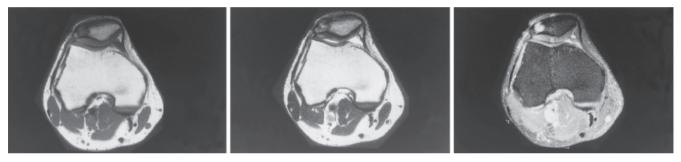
a Magnetic resonance imaging (MRI) reveals an intraosseous lesion showing iso-intensity in relation to the synovium on T1-weighted images; b MRI with heterogeneous
